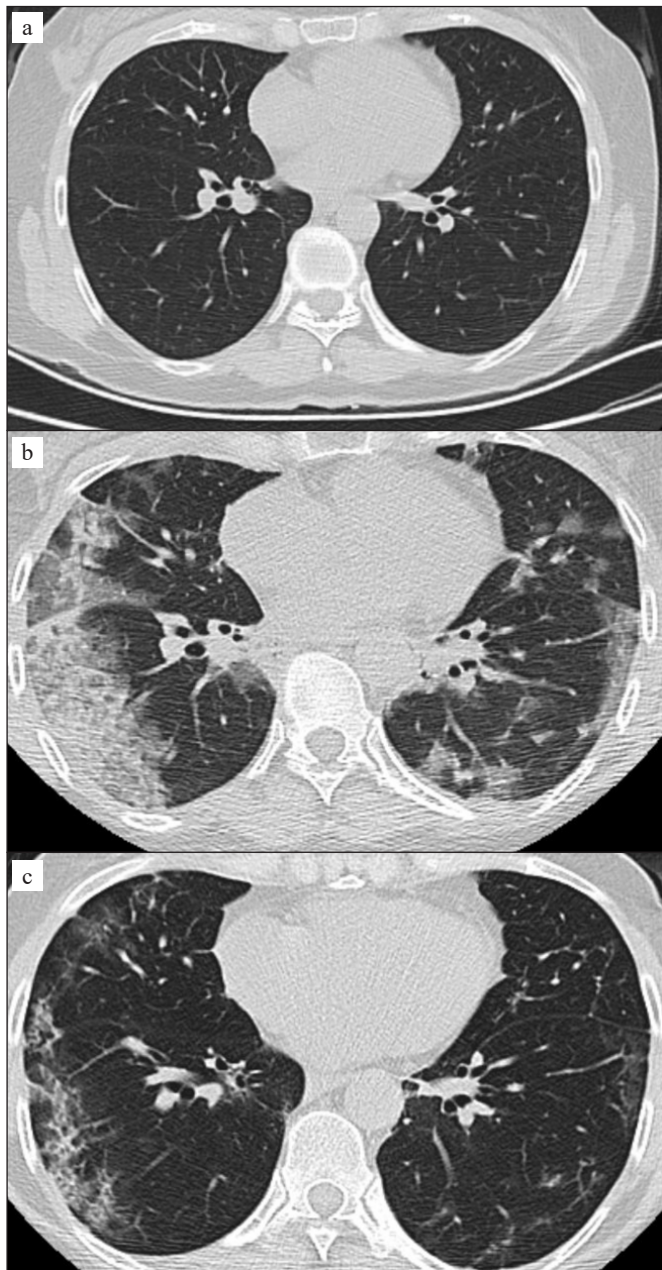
a-c. In three consecutive axial plane non-contrast CT images, (a) the first CT was normal, (b) the second CT showed peripherally located ground glass opacity, consolidation, and crazy paving pattern areas in both lungs. (c) On the third CT, the lesions appear to regress and linear band formations are observed [(a) CT-SS1=0; (b) CT-SS2=19; (c) CT-SS3=13].
